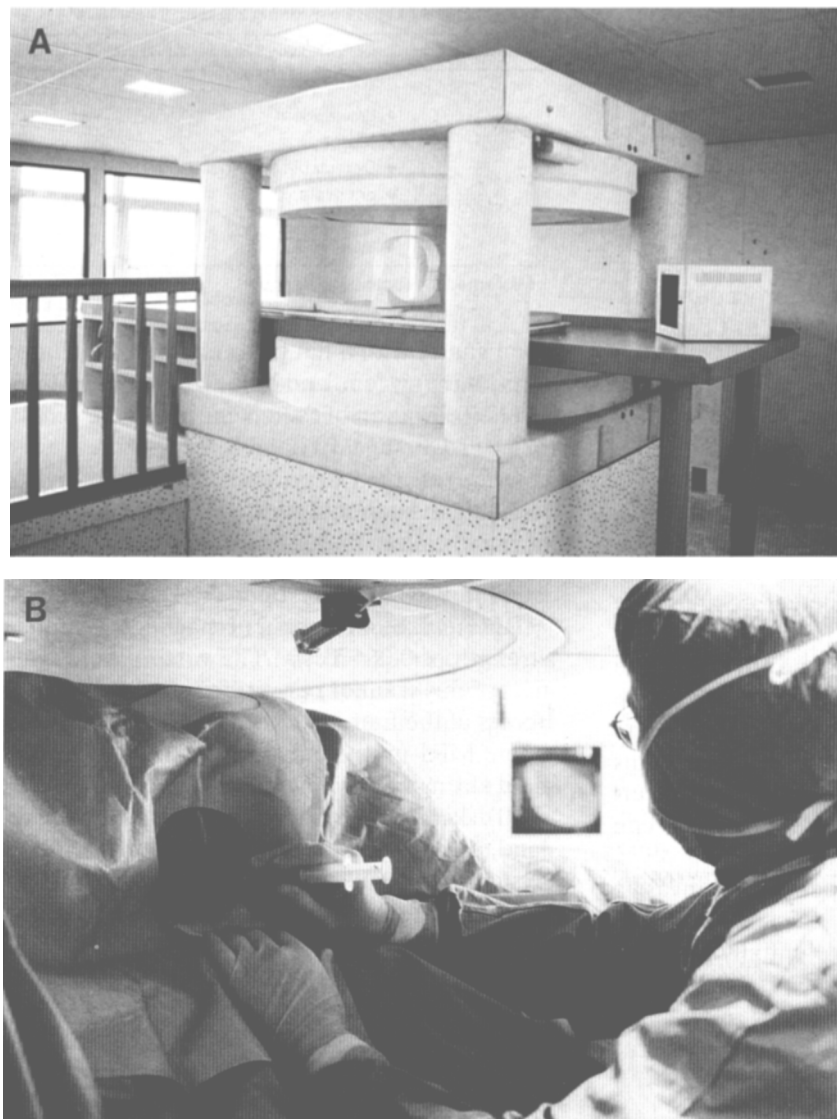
(A) Hybrid open MRI Facility with a Toshiba ACCESS MRI scanner. (B) Minimally invasive therapy inside the magnet.
